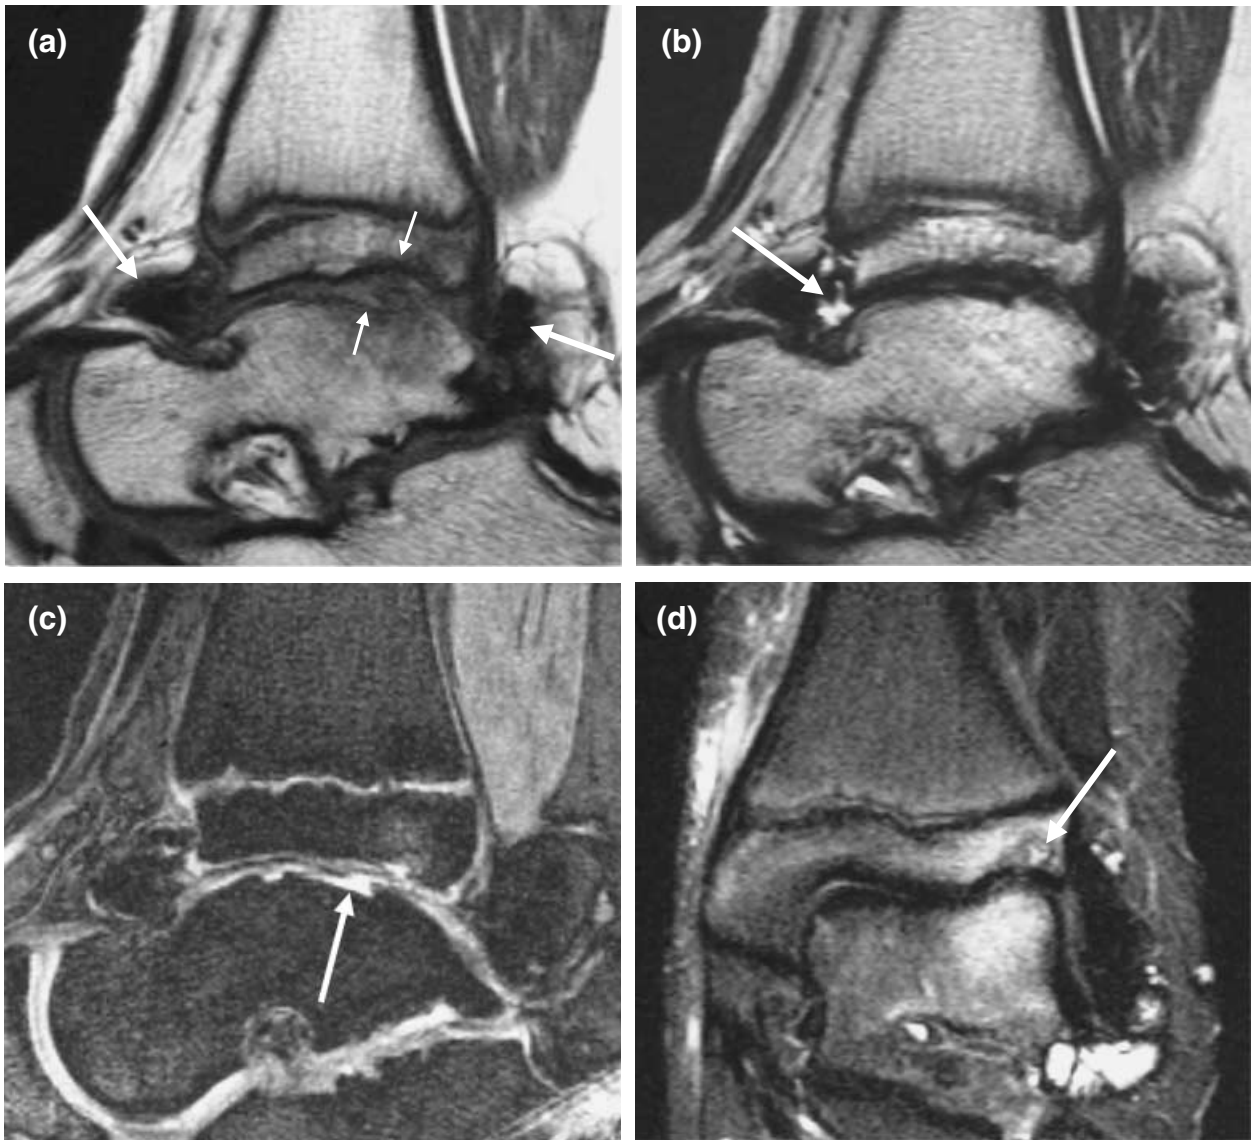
Left ankle of 12-year-old boy with moderate haemophilia. A. By consensus, this joint was assigned a Denver score of 10 and a European score of 8(2:3:3). (a) Sagittal standard spin echo (SE) T1-weighted sequence (TR 418 ms, TE 12 ms, slice thickness 3 mm, field of view 100 mm, matrix 184 × 256, two acquisitions). The image shows irregularity/erosion of subchondral cortex of the tibia and talus (small arrows), as well as hypertrophic synovia with haemosiderin depositions (haemosiderin is black, large arrows). (b) Sagittal turbo spin echo (TSE) T2-weighted sequence (TR 4200 ms, TE 96 ms, echo train 7, slice thickness 3 mm, field of view 100 mm, matrix 154 × 256, two acquisitions). The scan detects effusion (fluid is bright, arrow). (c) Sagittal fat suppressed 3D gradient echo (GE) sequence (TR 50 ms, TE 11 ms, flip angle 40°, slice thickness 1.5 mm, field of view 100 mm, matrix 228 × 256, one acquisition). The image shows destruction of talar cartilage (joint fluid in defect is bright, arrow). (d) Coronal short tau inversion recovery (STIR) sequence (TI 150 ms TR 4500 ms, TE 60 ms, slice thickness 4 mm, field of view 113 mm, matrix 198 × 256, three acquisitions). The scan reveals subchondral cyst in tibia (arrow).
